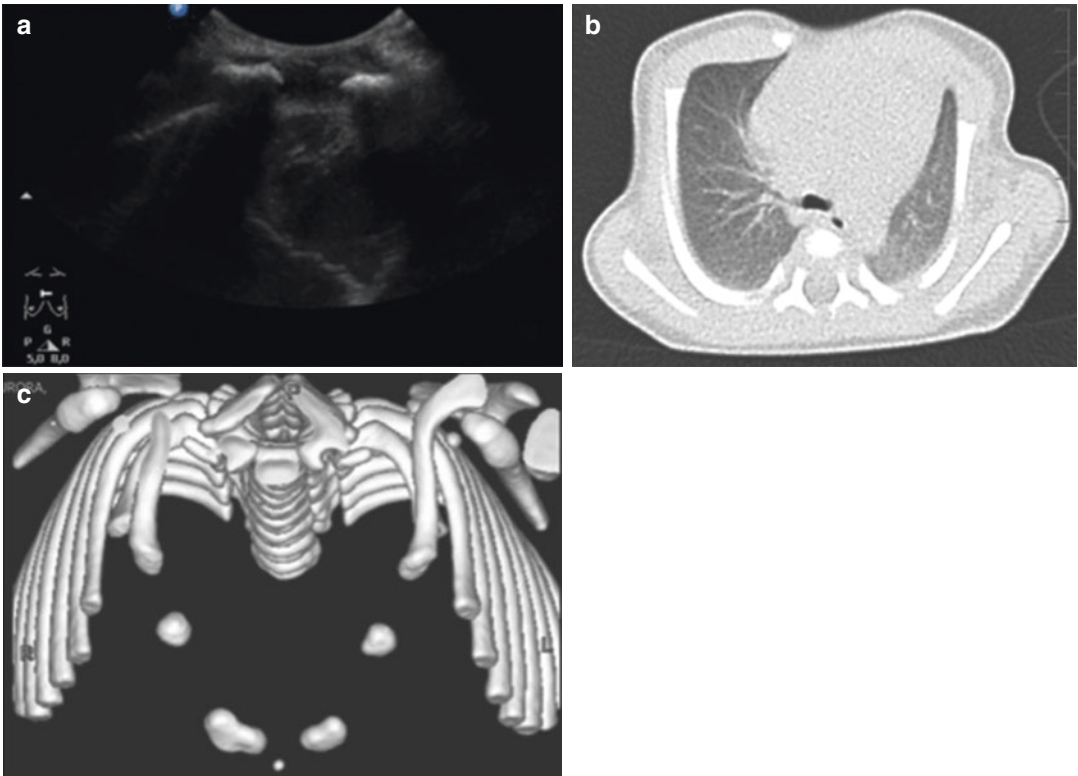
(a) US showing “V-shaped” sternum with proximal diastasis; (b, c) CT evaluation of the sternal deformity: diastasis of the middle and proximal portion of the sternum, costal hypoplasia
